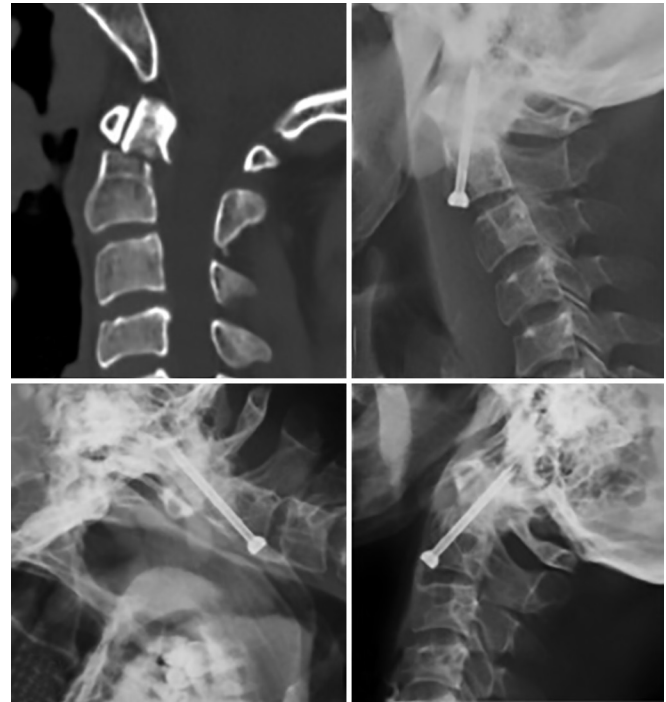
34-year old male with a posteriorly displaced type II odontoid fracture. (a) Preoperative CT sagittal images showing the displaced fracture. This patient underwent an anterior odontoid screw fixation and the immediate postoperative lateral radiograph showed good reduction of the fracture (b). 3-year follow-up lateral radiographs show the anterior odontoid screw in situ and bony fusion, with no evidence of instability on flexion (c) or extension (d) images.
